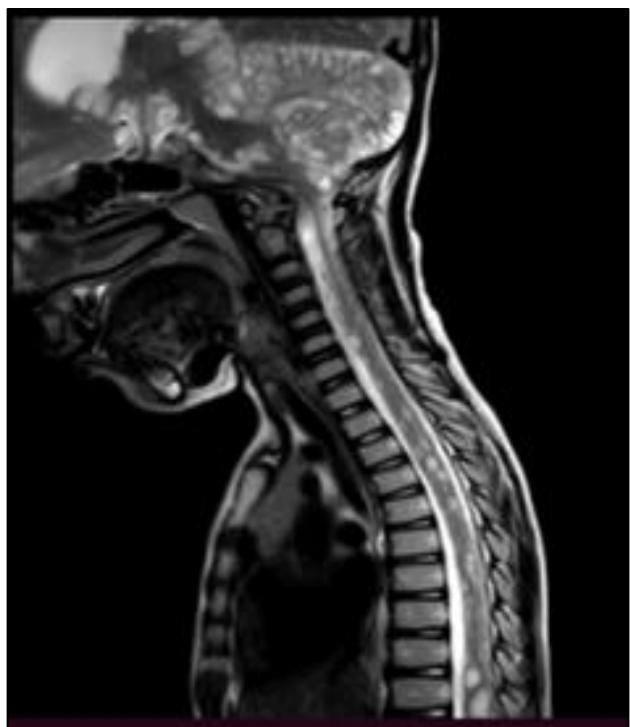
Sagittal T2-weighted image of the cervicothoracic spine shows cystic lesions involving brain and spinal cord.
